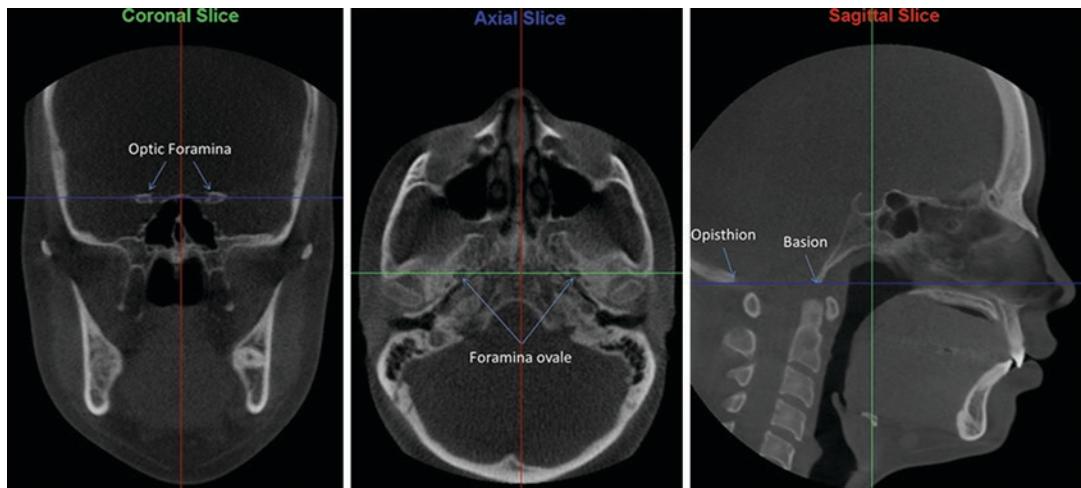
CBCT head orientation using the three planes of space (following Wu et al. orientation method)
